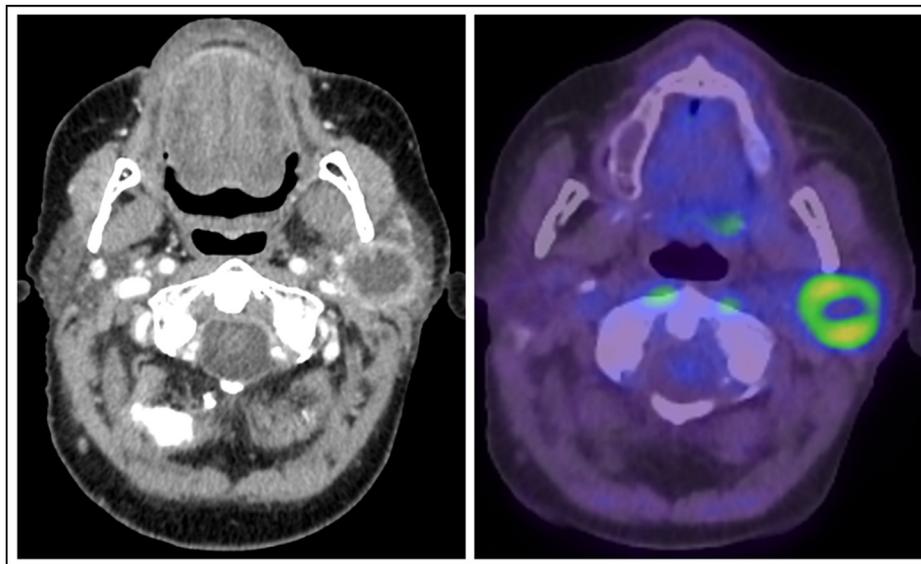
Cross-sectional imaging of a cutaneous SCC metastatic to parotid. (A) Contrast enhanced CT scan. (B) PET/CT.
